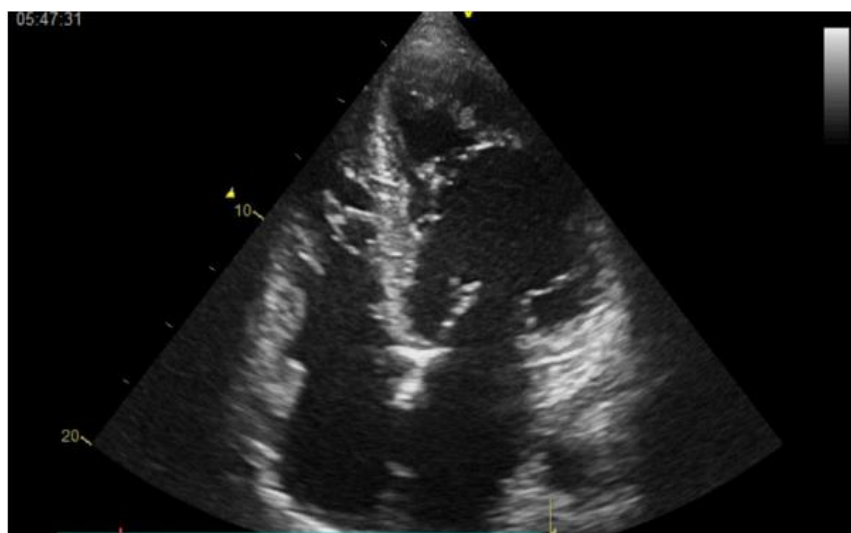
4 cavity echocardiography showing the left ventricle trabeculations
